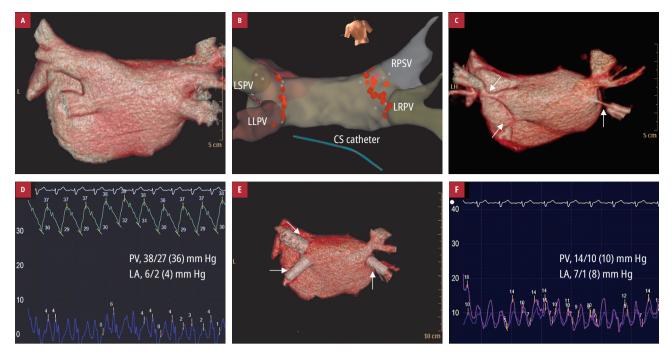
A – computed tomography reconstruction of the left atrium (LA) and pulmonary veins (PVs) before ablation; B – LA and PV reconstruction using NavX<sup>™</sup>. Red dots correspond with radio frequency applications. C – the LA and PVs after ablation; severe stenosis of 3 veins (arrows); D – hemodynamic parameters in the LA and PV before treatment; E – final result after treatment with 3 stents (arrows); F – hemodynamic parameters after treatment Abbreviations: CS, coronary sinus; LSPV, left superior pulmonary vein; LLPV, lower left pulmonary vein; RSPV, right superior pulmonary vein; LRPV, lower right pulmonary vein
